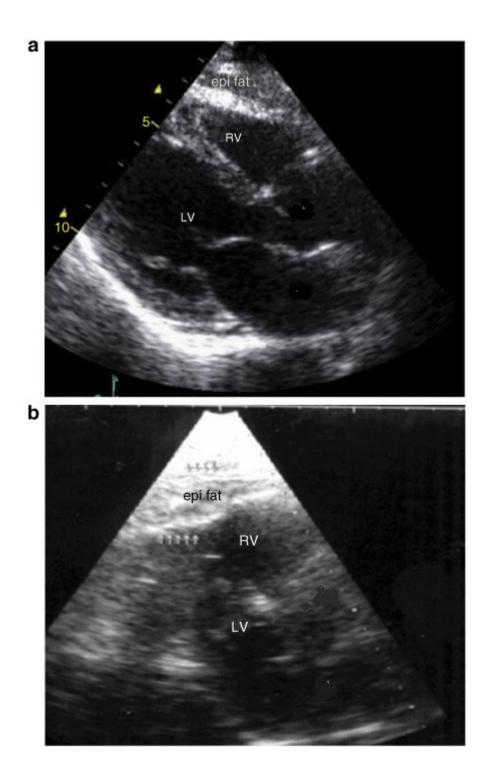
Echocardiographic epicardial fat thickness. Epicardial fat (epi fat) is identified as (a) the echo-free space between the outer wall of the myocardium and the visceral layer of pericardium in the parasternal long-axis view or (b) as hyperechoic space (epi fat, within white arrows), if in massive amounts (>15 mm). Epicardial fat thickness (white line in a, black line in b) is measured at the point on the free wall of the right ventricle along the midline of the ultrasound beam, with the best effort to be perpendicular to the aortic annulus, anatomical landmark. LV, left ventricle; RV, right ventricle
